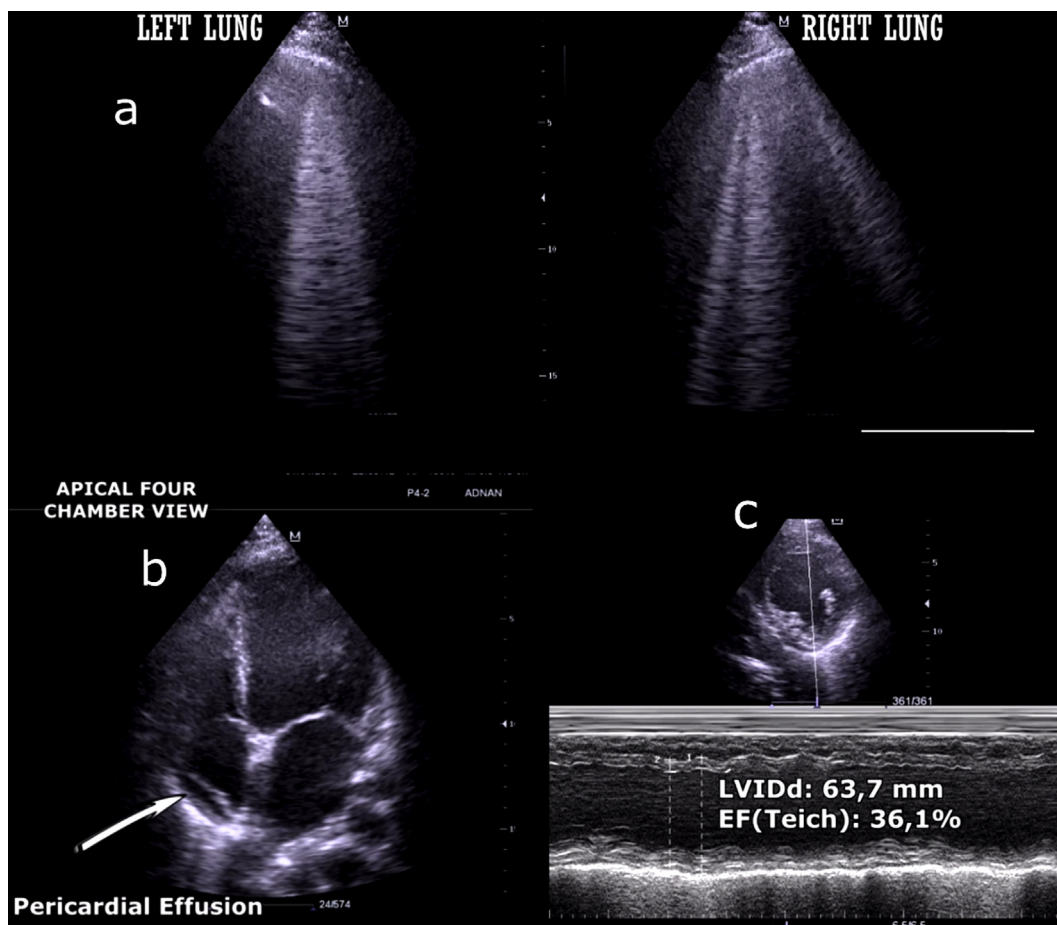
Lung and cardiac ultrasound. Figure 1a: Lung ultrasound showed multiple ultrasonographic B-lines both right and left middle lung zones. Figure 1b: Apical 4-chamber view showed dilated left ventricle and pericardial effusion around right atrium. Figure 1c: Evaluation of left ventricular systolic function via M-Mode at the parasternal short axis. The ejection fraction measured by the Teichholz method indicates left ventricular systolic dysfunction and left ventricular dilatation.
